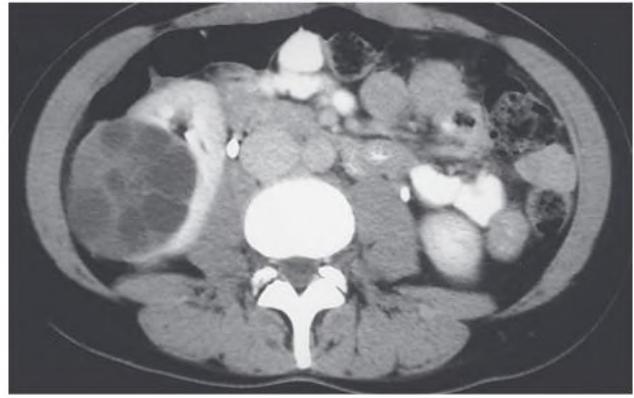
Solitary Multilocular Cyst. Contrast-enhanced computed tomography shows a solitary, septated, and well-circumscribed kidney cystic lesion in the right kidney.
